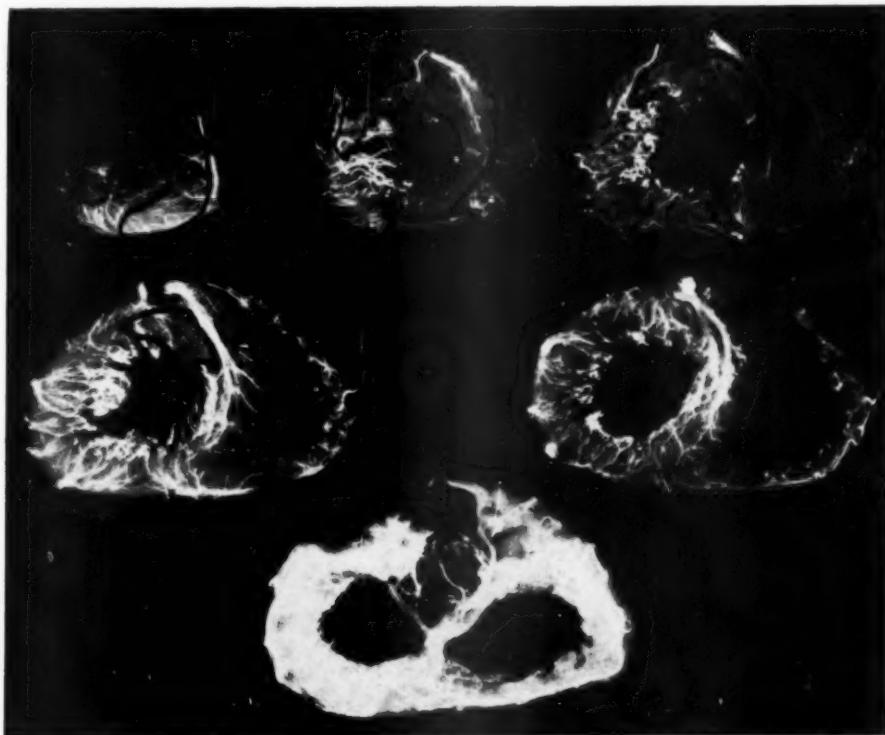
Roentgenogram of injected heart in Case 53.
